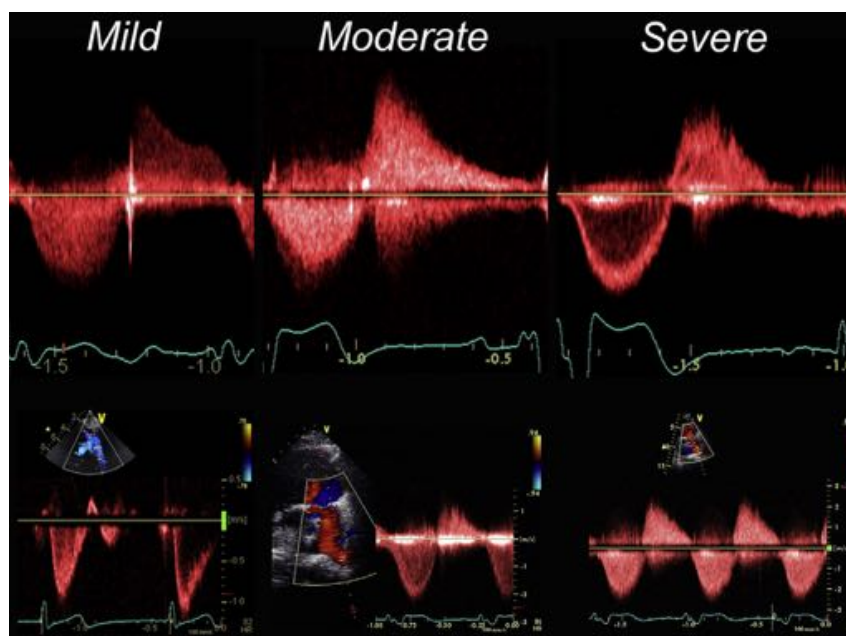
Evaluation of PR by Doppler echocardiography showing mild, moderate, and severe degrees. (Top row) Spectral Doppler tracing. Mild regurgitation is characterized by a persistent flow gradient at end-diastole and moderate regurgitation by equilibration of pressures between the MPA and right ventricle only at end-diastole, and severe regurgitation is associated with early diastolic pressure equilibration. (Bottom row) Pulse Doppler interrogation in the LPA showing degrees of diastolic flow reversal. See text for details.
